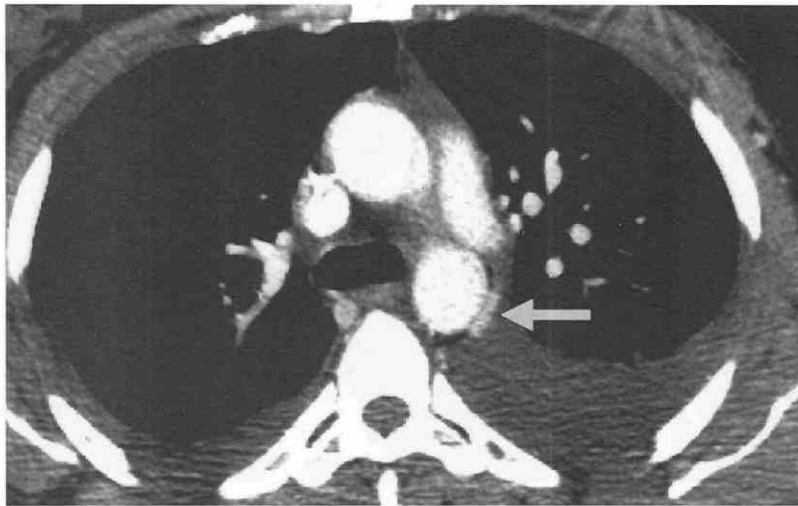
Axial CT scan demonstrates a suspicious soft tissue density (*arrow*) adjacent to the descending aorta.
